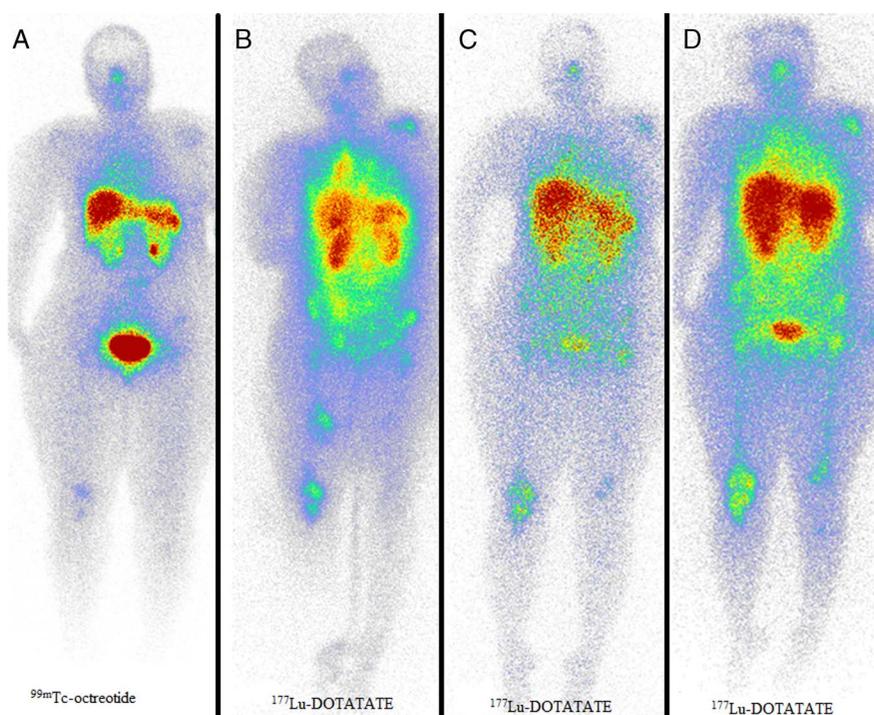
A 42-year-old woman with invasive ductal carcinoma underwent ^{99m}Tc-octreotide scintigraphy showing multiple bone metastases on the left shoulder, ribs, spinal cord, pelvic, right knee (A). Therefore, the patient was a candidate for PRRT with ¹⁷⁷Lu-DOTATATE. She received 3 cycles of PRRT that resulted in a partial response according to the post-PRRT cycle images (B–D) and a significant reduction in bone pain.
